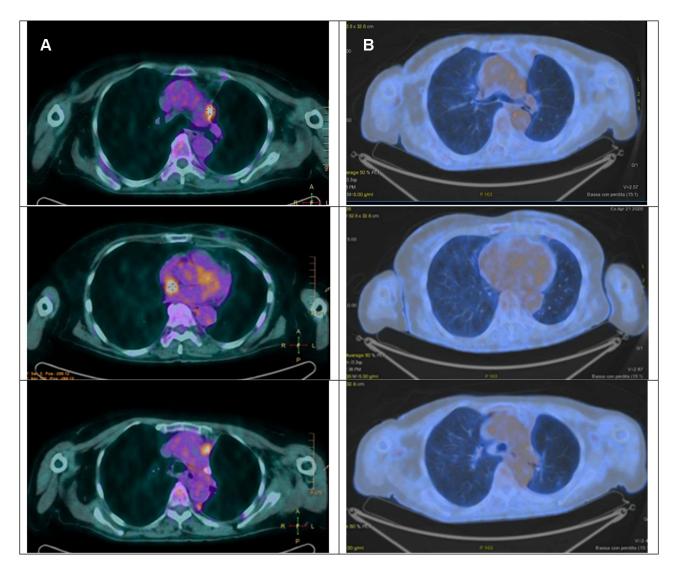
Figure I PET CT scan of the chest-mediastinal window. Neoplastic aorto-pulmonary, mediastinal para aortic and left paravertebral lymph nodes. (A) Baseline disease. (B) Complete disease response after 12 weeks of therapy with osimertinib.
